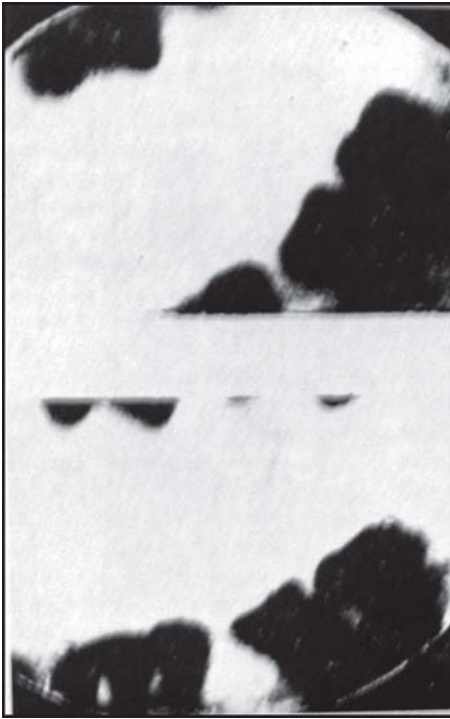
First dental radiographs, made by Dr Otto Walkhoff
